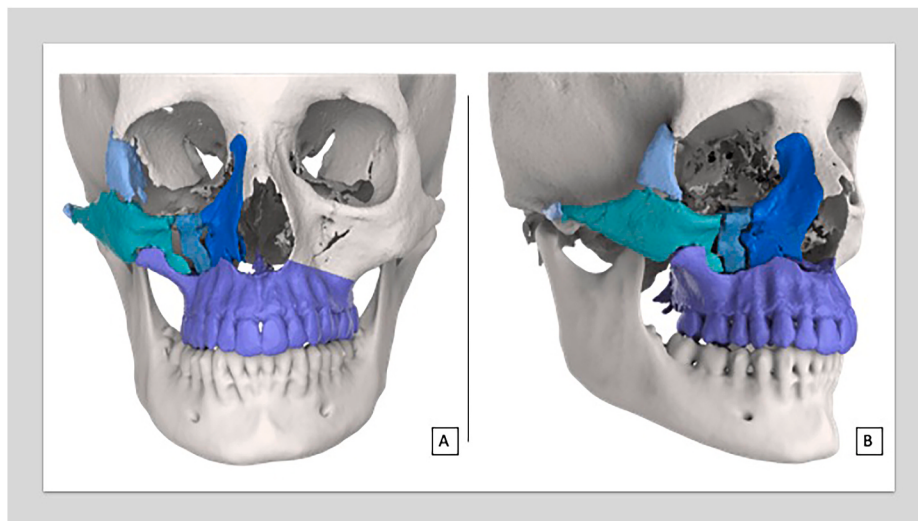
Preoperative extraction of a patient's CBCT data for planning. The figure shows representative views of (A) the frontal view and (B) the right-side view, revealing fractures in the orbito-malar-zygomatic complex (OMZ).
